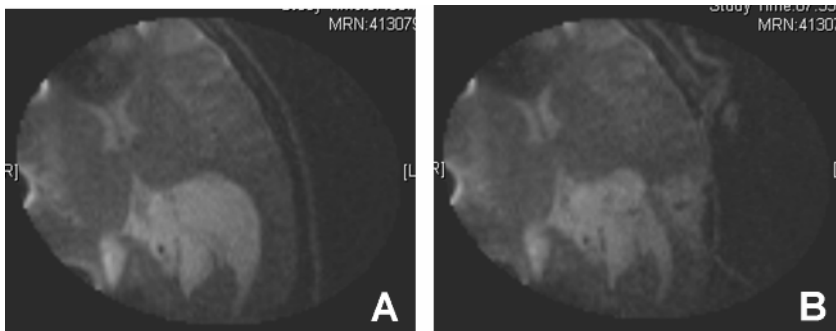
(A-B) Preoperative axial non-enhanced MRI showing the tumor location.
